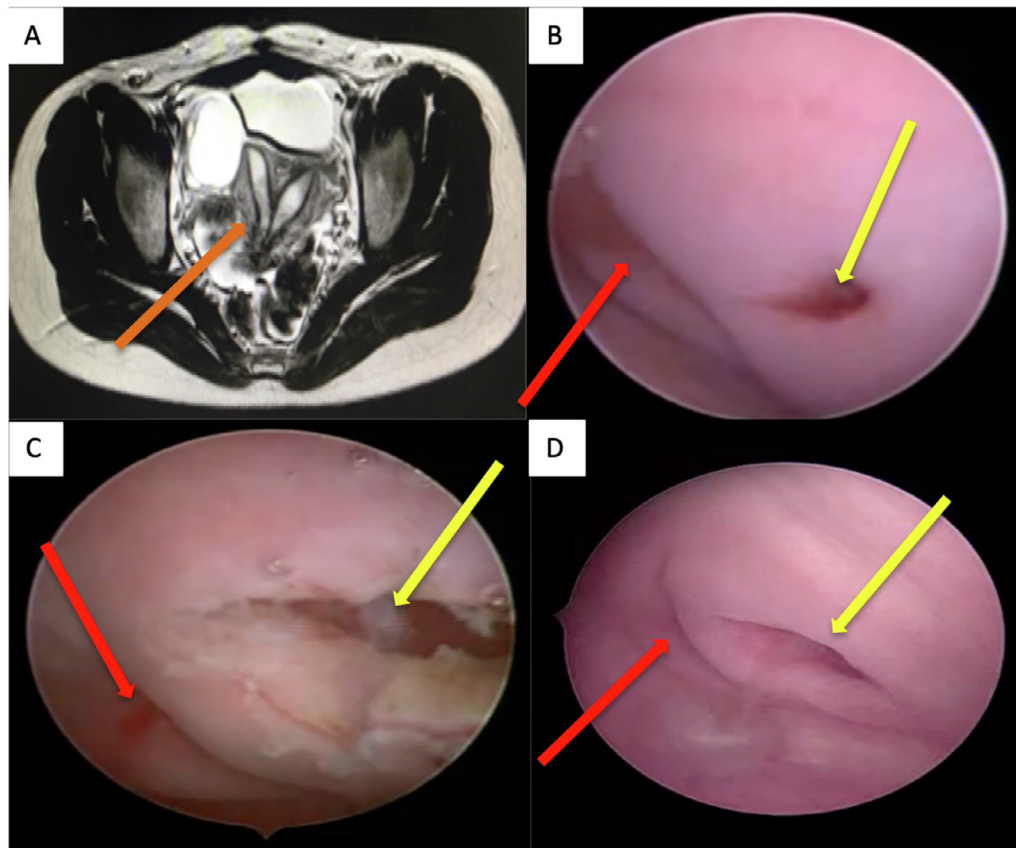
(A) Pelvic MRI depicting complete septate uterus (orange arrow), (B) vaginoscopic image with the hysteroscope showing two external cervical os, (C) image after the surgery, and (D) follow up image indicating both the external os as normal external cervical os (red arrow indicates normal right external os whereas yellow arrow indicates stenosed left external cervical os in Fig B,C and D).
